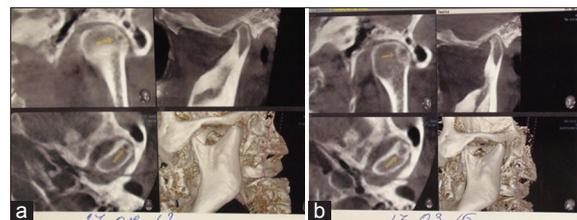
Computed tomography of patient D.: (a) - 2012, (b) - 2015. In dynamics, an increase in the radiobacillarity of the left articular head (indicated by an arrow) and a decrease in the lumen of the joint space
